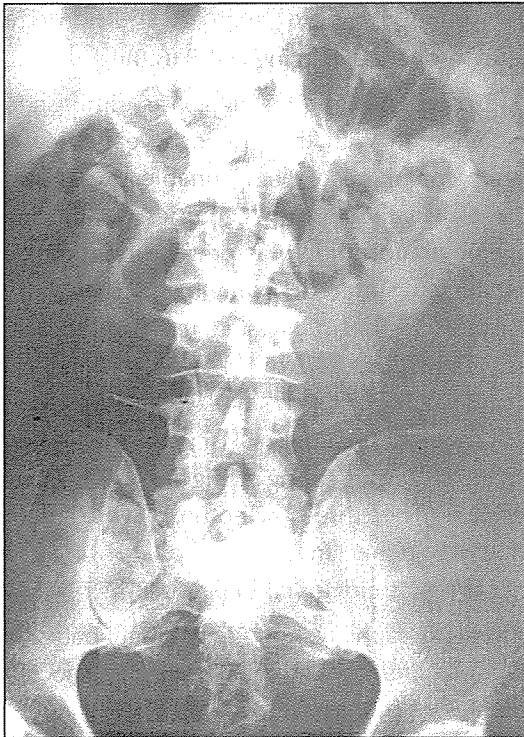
Preoperative antero-posterior roentgenogram.
